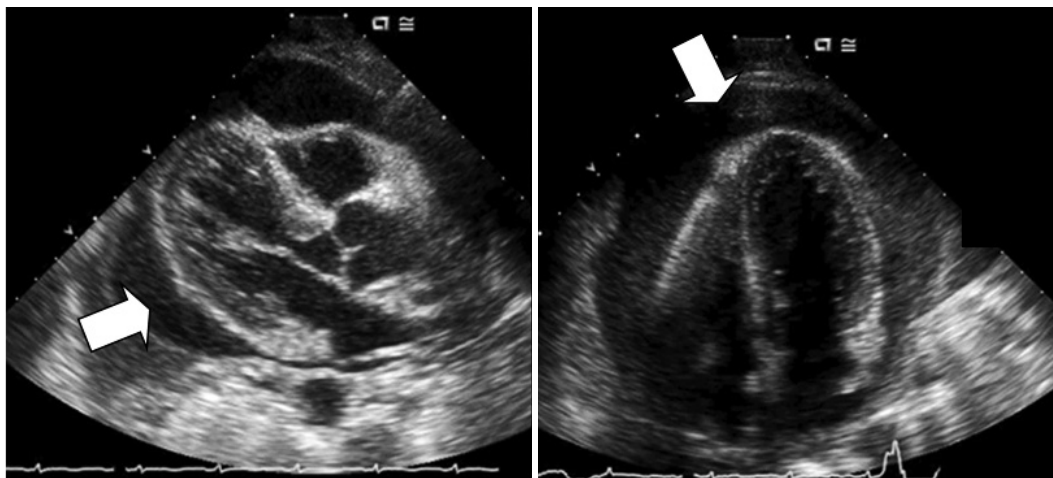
Representative images of echo-free space on 2-dimensional echocardiography.
